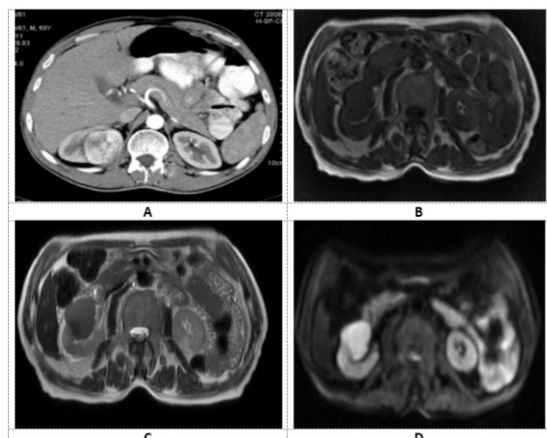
1 Axial CECT and MRI images in a 50 year old male shows a lesion in right kidney. Axial Contrast enhanced CT shows homogeneously enhanced mass lesion (A). Axial MRI images shows a well-defined lesion in right kidney which is hypo-intense on T1 and T2WI (B and C) and shows restricted diffusion on DWI (D). Diagnosis- Renal Cell Carcinoma
